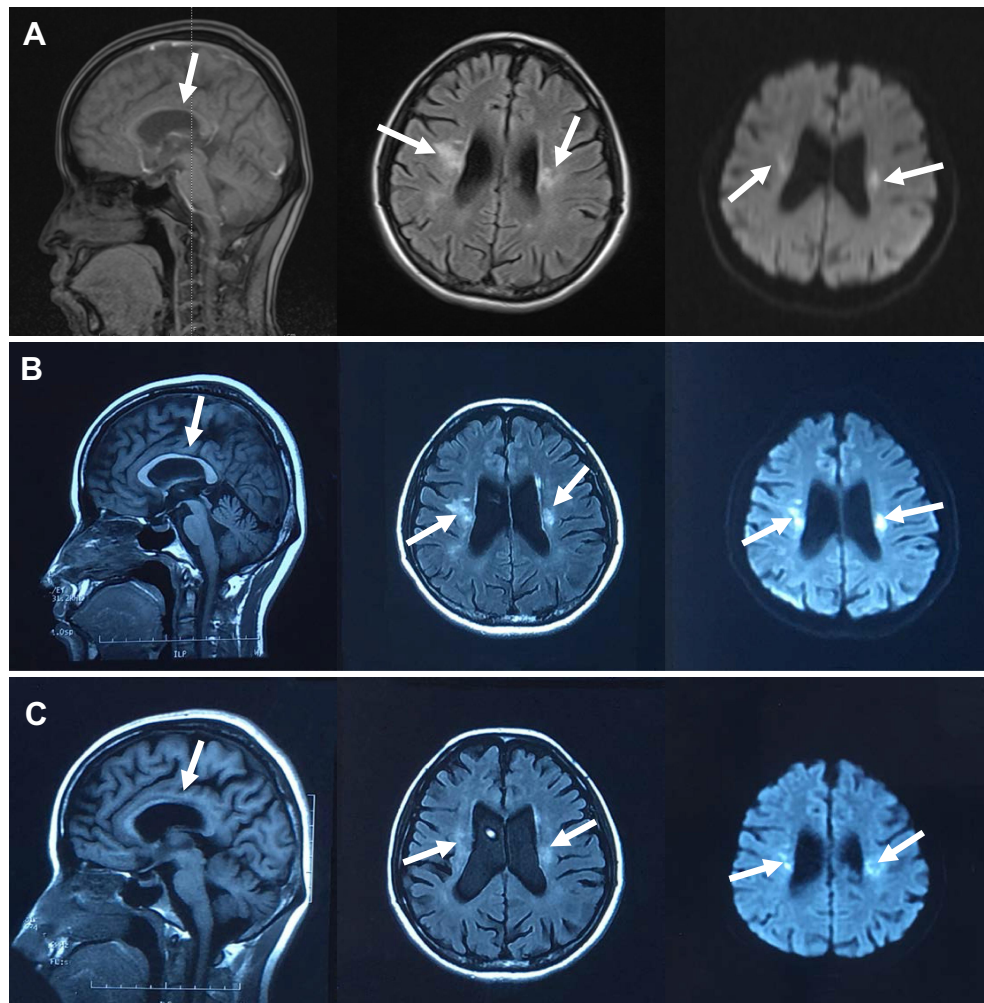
MRI features of *CSFIR*-related leukoencephalopathy. (A) T1-weighted sagittal images showed thinning of the corpus callosum (arrows). Fluid-attenuated inversion recovery (FLAIR) and diffusion weighted imaging (DWI) images showed periventricular white matter hyperintensities, abnormal signals on bilateral semi-oval centers (arrows). Global brain atrophy was noted. MRI was taken on 13th, June, 2019. (B) T1-weighted sagittal images showed that the corpus callosum is thinner than the last time (arrows). FLAIR images showed increased diffuse white matter lesions and the progression of global brain atrophy (arrows). DWI images revealed various isolated spots of hyperintense signals. MRI was taken on 08th, July, 2019. (C) Repeated MRI scans were taken on 10th, October, 2019. White arrows represent the brain lesions.
